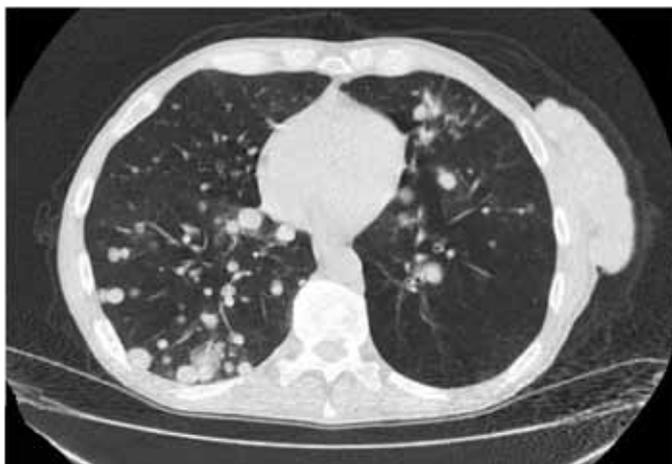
Computed tomography scan of the chest demonstrated multiple pulmonary nodules up to 2.5 cm in size.
